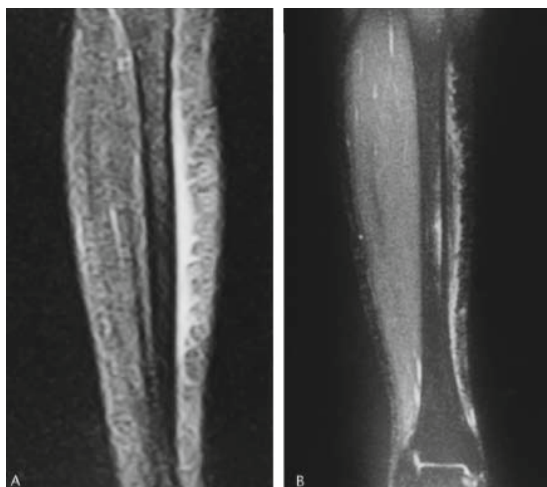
2b: Coronal MRI images showing abnormally high signal on the medial side of the tibia (fig 2.2a) and abnormally high signal along the medial border and the medial side of the bone marrow (fig 2.2b) [3].
